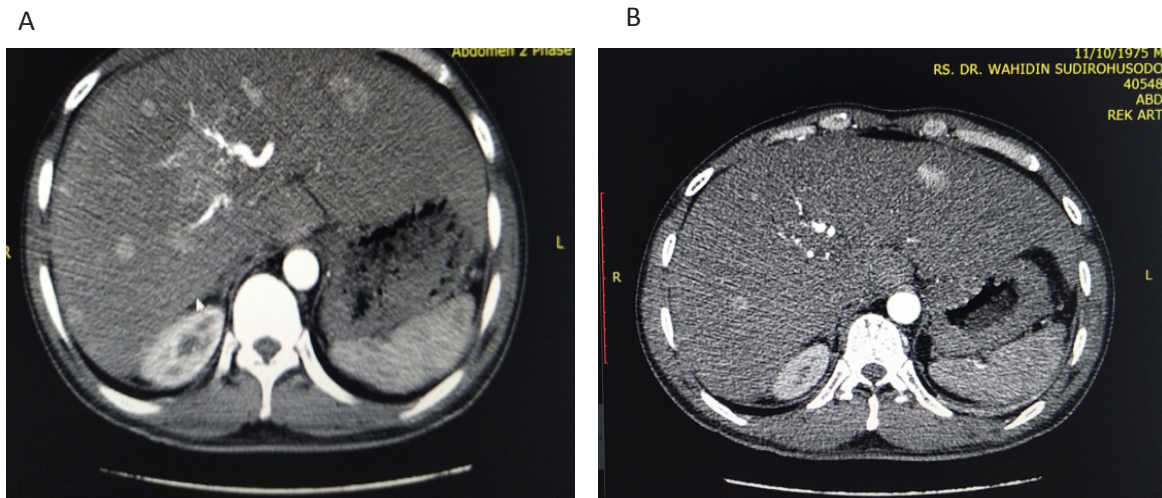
A. An axial cut of multiphase abdominal CT shows several small lesions in the liver with intratumoral enhancement in the arterial phase which identified as non-target lesions. The main tumor was on another cut of the image. B. One month after undergoing TACE therapy, in the same cut as the previous picture, lipiodol retention was seen in the branches of the right hepatic artery with a reduction in the number of lesions. Persistent intratumoral enhancement was seen in several non-target lesions. This finding identified as an incomplete response or stable disease of non-target lesions.
